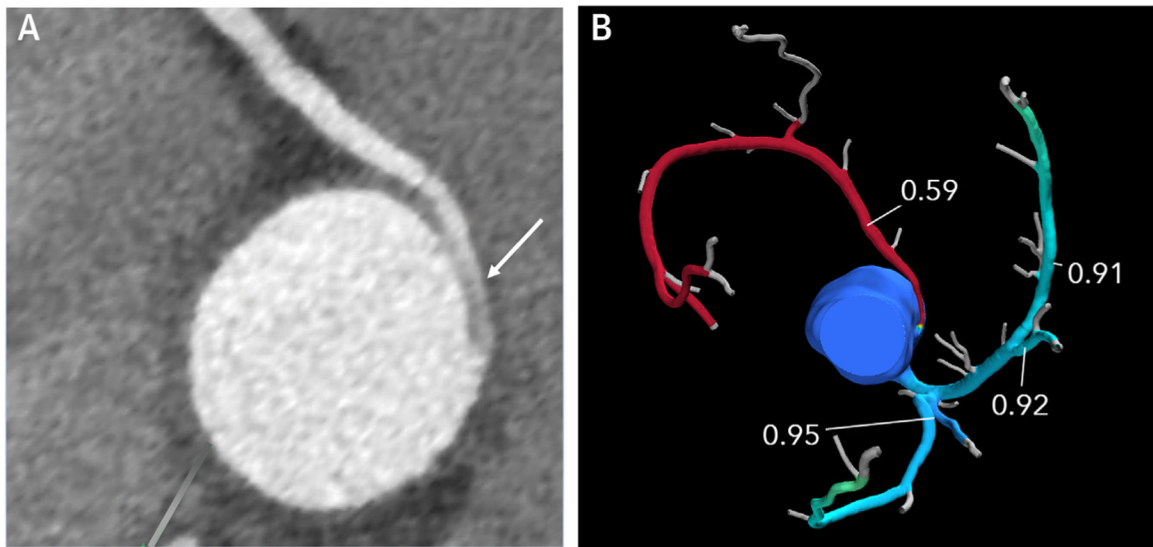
Computed Tomographic Fractional Flow Reserve (CT FFR)
